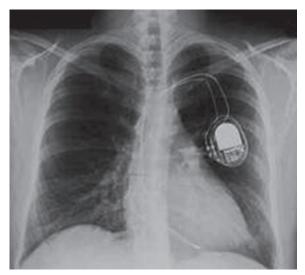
X-ray with CIED in situ
